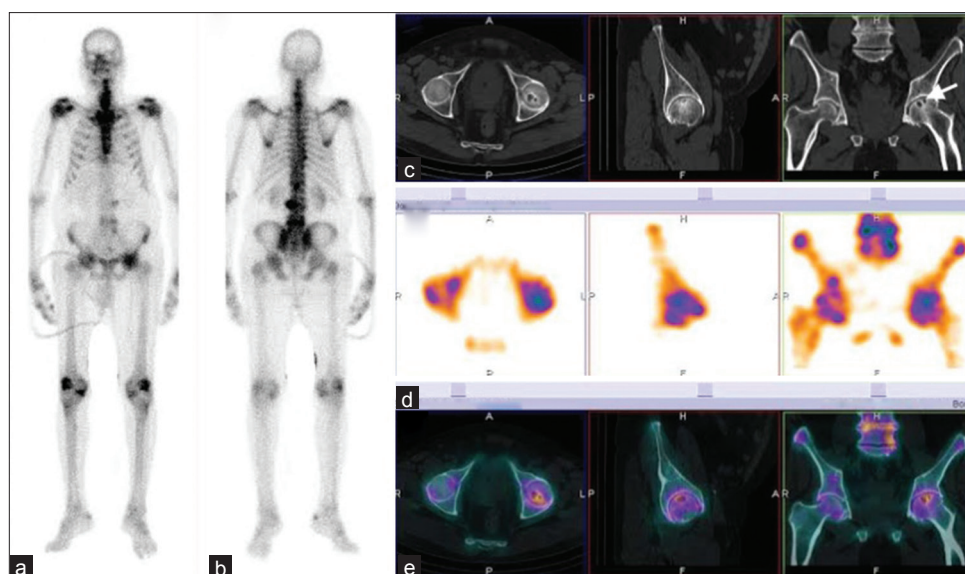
^{99m}Tc -methylene diphosphonate planar skeletal scintigraphy anterior and (a) posterior (b) views showing an abnormal focal increased tracer uptake in left femur head and lateral aspect of L4 and L5 vertebrae. On single positron emission computed tomography/computed tomography (SPECT/CT), (c-e) the increased tracer uptake in the left femoral head localized to subchondral cystic (white arrow on SPCT/CT images) with minimal sclerotic but no change in the size femur head changes on CT images
